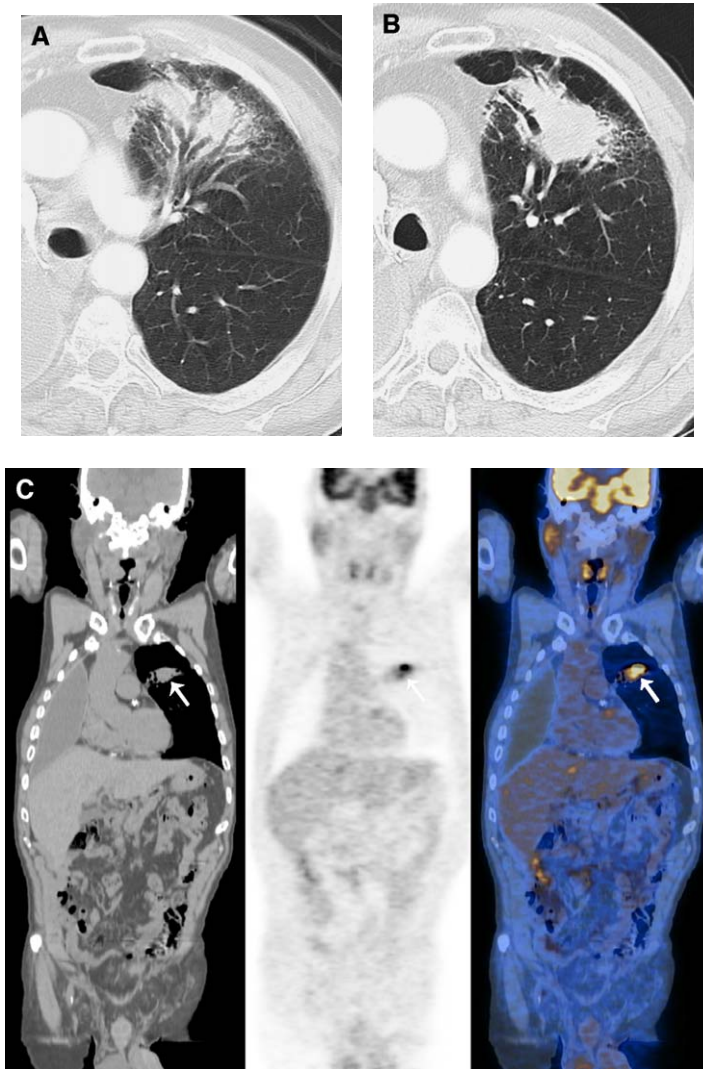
A 72-year-old man who had undergone right pneumonectomy for squamous cell carcinoma developed a new left upper lobe nodule that was treated with radiation therapy. (A) Follow-up CT at 6 months demonstrated signs of evolving radiation fibrosis, manifesting as linear opacities associated with volume loss and traction bronchiectasis. (B) Follow-up CT at 14 months demonstrated a new area of mass-like consolidation within the radiation fibrosis. (C) Coronal fused PET-CT shows FDG activity within the mass (*arrow*) consistent with recurrent disease.
